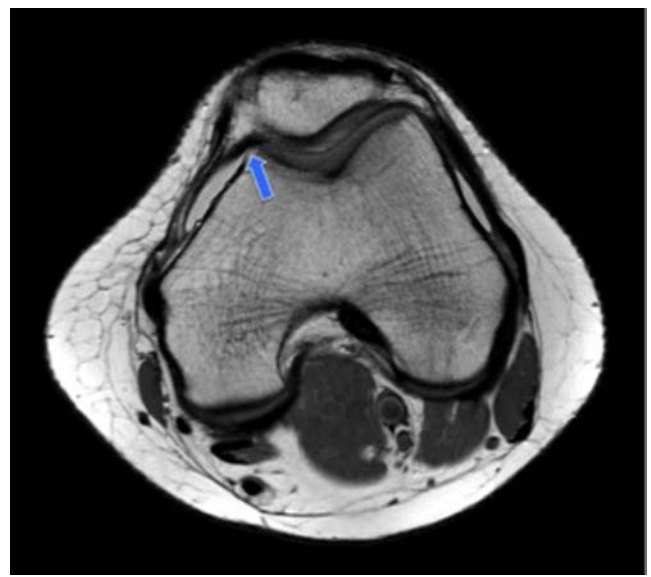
Magnetic resonance image in axial plane T1 weighted demonstrating the well-formed band of fibrous tissue (blue arrow) arising from the medial capsule around the femoral condyle to the anterior horn of the medial meniscus.
